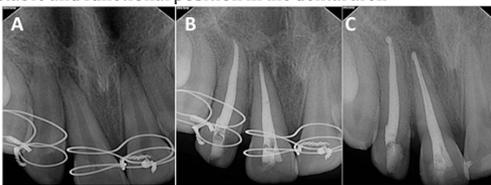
Intraoral Periapical radiograph Fig1 A: Teeth with splint and closed apices Fig1B: Calcium hydroxide dressing Fig1C: Calcium hydroxide dressing at 1mth.
